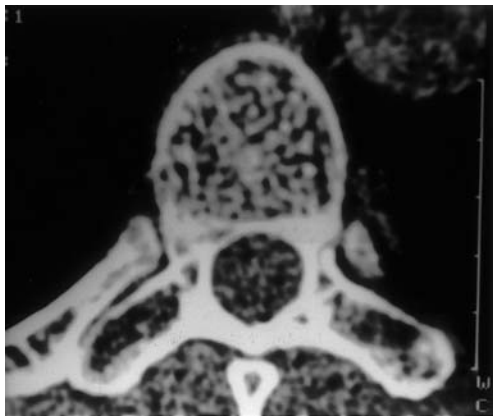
Axial CT section demonstrates the “polka dot” appearance of the vertebral body, which is pathognomonic for hemangioma
